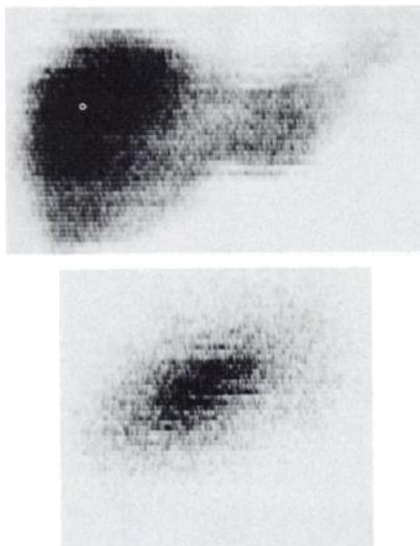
Anterior (top) and left lateral (bottom) spleen scintigraphs 9 months after splenectomy (12/9/74).
